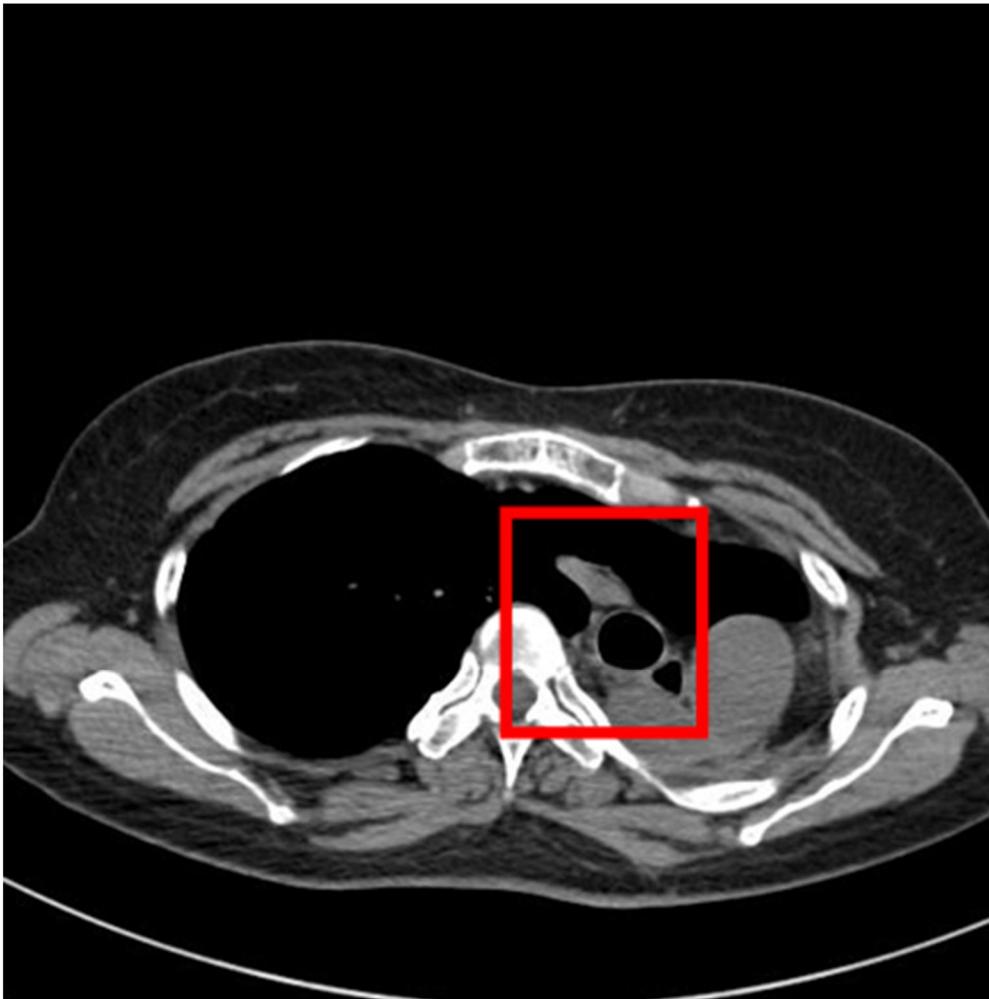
Chest CT: Prominent leftward shift of esophagus, trachea, mediastinum
